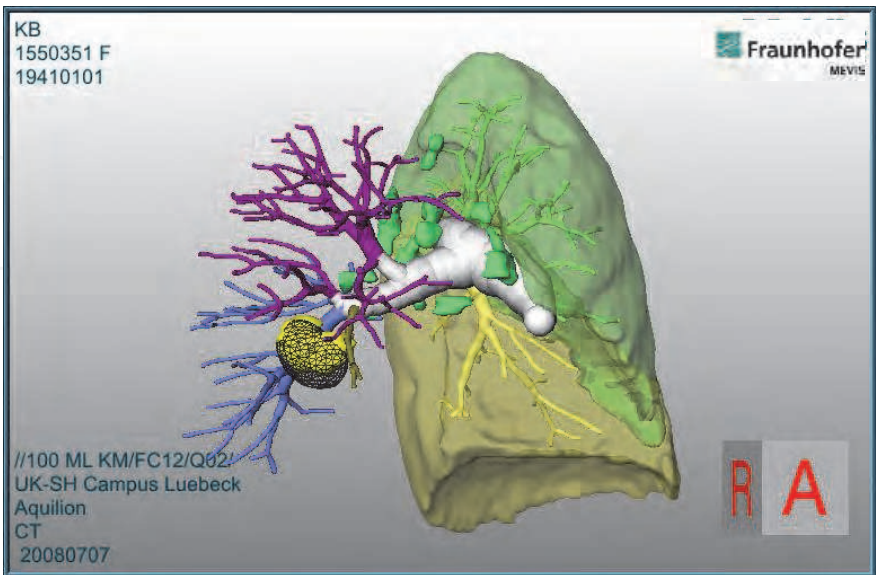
PET-CT image fusion. Clear superimposition of metabolically active areas on the F18-PET (black grid lines) with the tumor (yellow).
